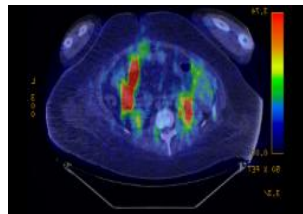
FDG PET Scan revealed large transverse colonic mass with increased metabolic activity.
